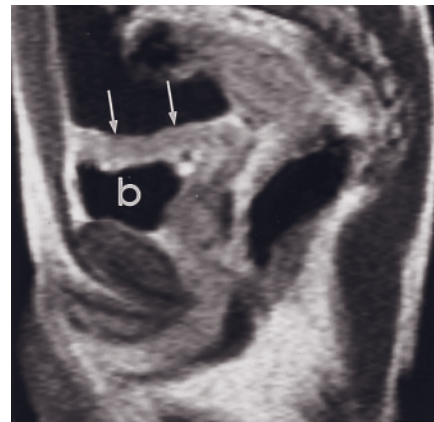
(Continued) T1-weighted gadolinium-enhanced SGE (b, c), and T1-weighted gadolinium-enhanced fat-suppressed SGE (d) images in a patient with prostate cancer. The bladder wall is diffusely thickened (a, b) and shows heterogeneous enhancement of the anterior wall. The prostate gland is irregularly enlarged and enhances heterogeneously after contrast administration (b, c). A nodule of tumor, extending superiorly from the prostate to the trigone region, enhances substantially (arrow, c). Note multiple bone metastases in the iliac wings that appear as high-signal enhancing foci (d). T1-weighted SGE (e), T2-weighted single-shot echo-train spin-echo (f), and T1-weighted postgadolinium SGE (g) images in a second patient with recurrent prostate cancer invading the bladder. Tumor is intermediate in signal intensity on T1 (arrow, e) and T2 (arrow, f)-weighted images and enhances minimally with gadolinium (arrow, g).
